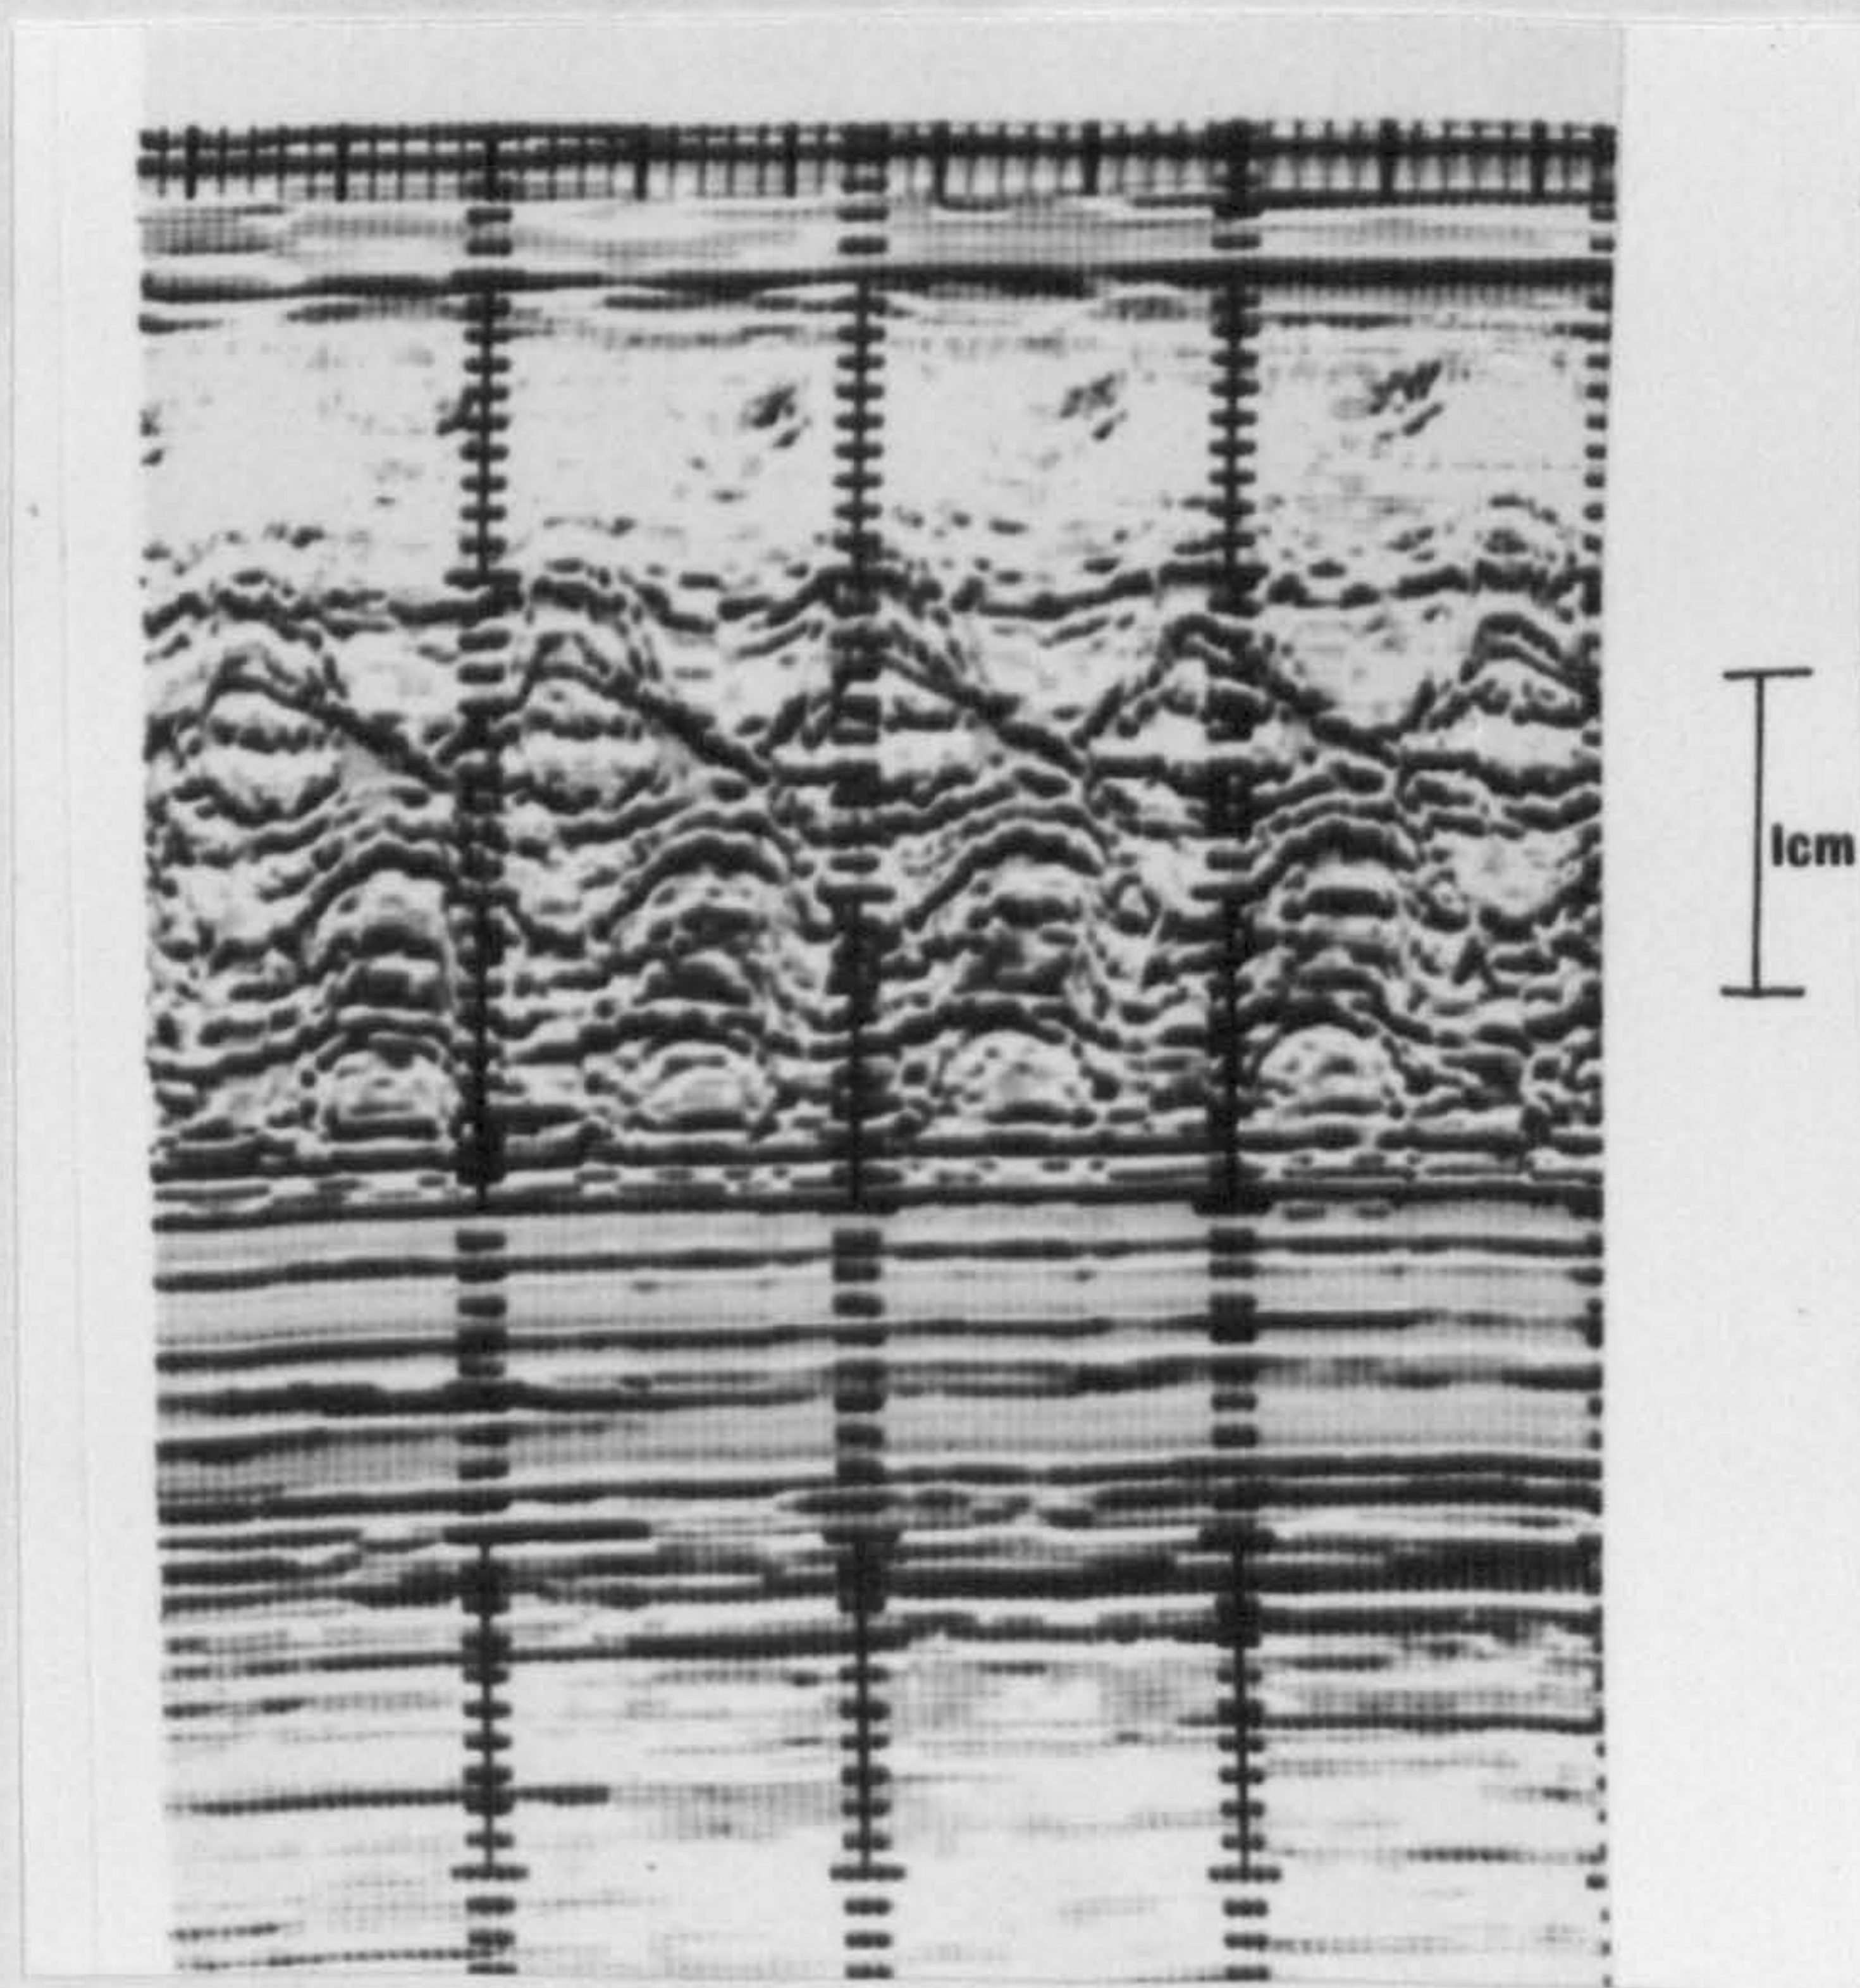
Case 4. M mode echocardiogram in the same case as the above figure. Measurement of the septum and left ventricular wall lay outside the 95th percentile for these measurements at this gestational age.
